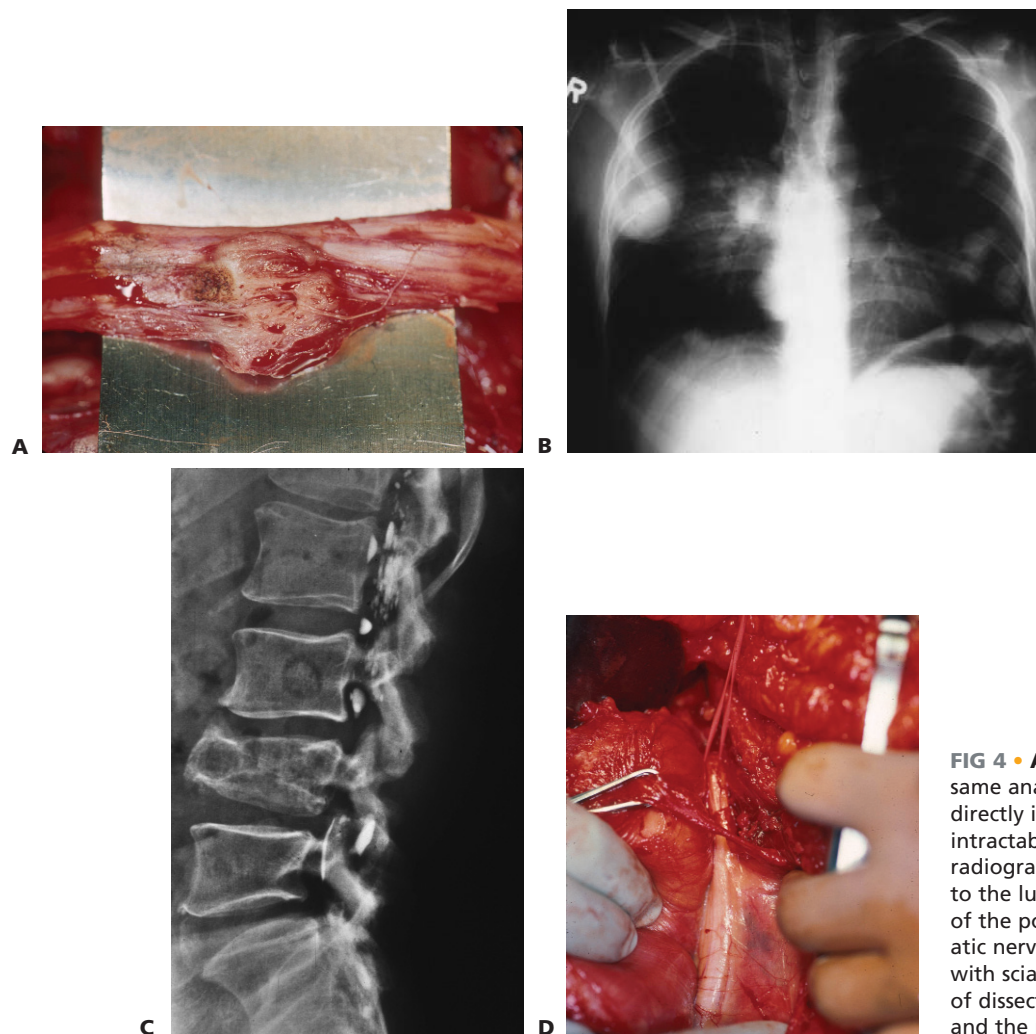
• A. Metastatic carcinoma at the same anatomic location penetrating directly into the nerve and causing an intractable, agonizing sciatic pain. Plain radiographs show metastatic osteosarcoma to the lungs (B) and L3 (C). D. Liposarcoma of the posterior thigh extending to the sciatic nerve. Although the patient presented with sciatic pain, there was a clear plane of dissection between the tumor capsule and the nerve.
